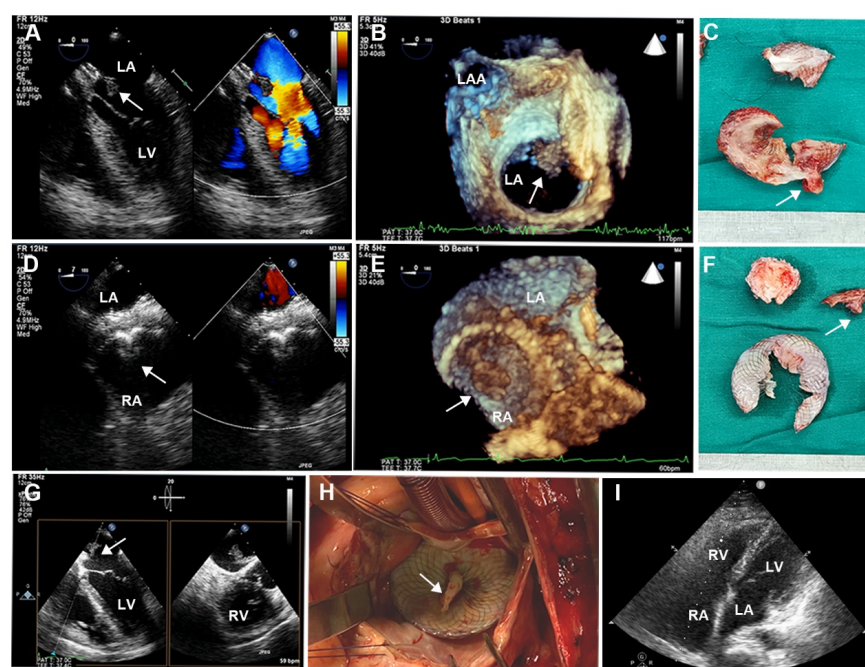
Intraoperative TEE, postoperative TTE, and surgical images. (A) and (D) 2D-TTE color Doppler showed an ASD device with double-sided thrombus. (B) and (E) 3D-TTE demonstrated a fan-like left-atrial thrombus attached to the device and a short rod-like right-atrial thrombus attached to the device. (C) and (F) Surgical resection of ASD device fragments with bilateral thrombus. (G) Biplanar TTE showed a giant thrombus floating in the left atrium. (H) Left atriotomy showed white thrombus attached to the device. (I) Postoperative TTE showed continuous atrial septum without shunt and thrombus. TEE, transesophageal echocardiography; TTE, transthoracic echocardiography; ASD, atrial septal defect. White arrows represent thrombus.
